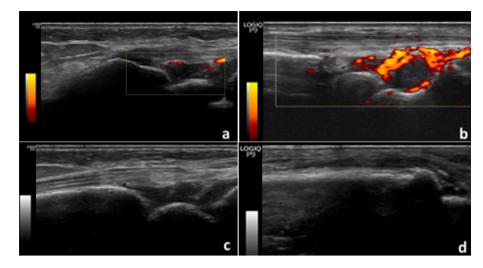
(a and b) Power Doppler ultrasonography showing variable grades of increasedvascularity within the hypertrophied synovium at the wrist joint denoting synovitis in a rheumatoid arthritis patient. (c):Dorsal longitudinal grey scan of wrist joint showing joint cavity enlargement due to hypoechoic synovial fluid as well as hyperechoic synovial thickening. (d): Dorsal longitudinal scan of 2nd metacarpophalangeal (MCP) joint showing synovial hypertrophy along with effusion.
